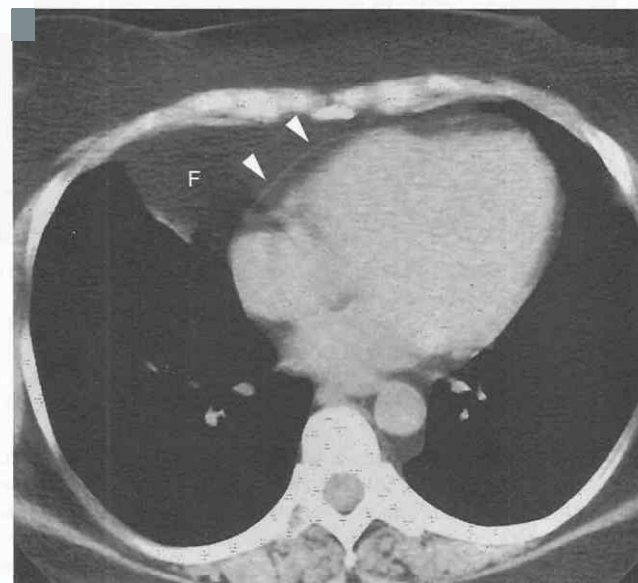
Prominent paracardiac mediastinal fat. This patient was evaluated by CT for a masslike density at the right cardiophrenic angle. Axial CT scan without contrast medium shows a collection of fat (F) at the right cardiophrenic angle, consistent with a prominent fat pad. The thin pericardium is outlined by subepicardial and mediastinal fat (arrowheads).
